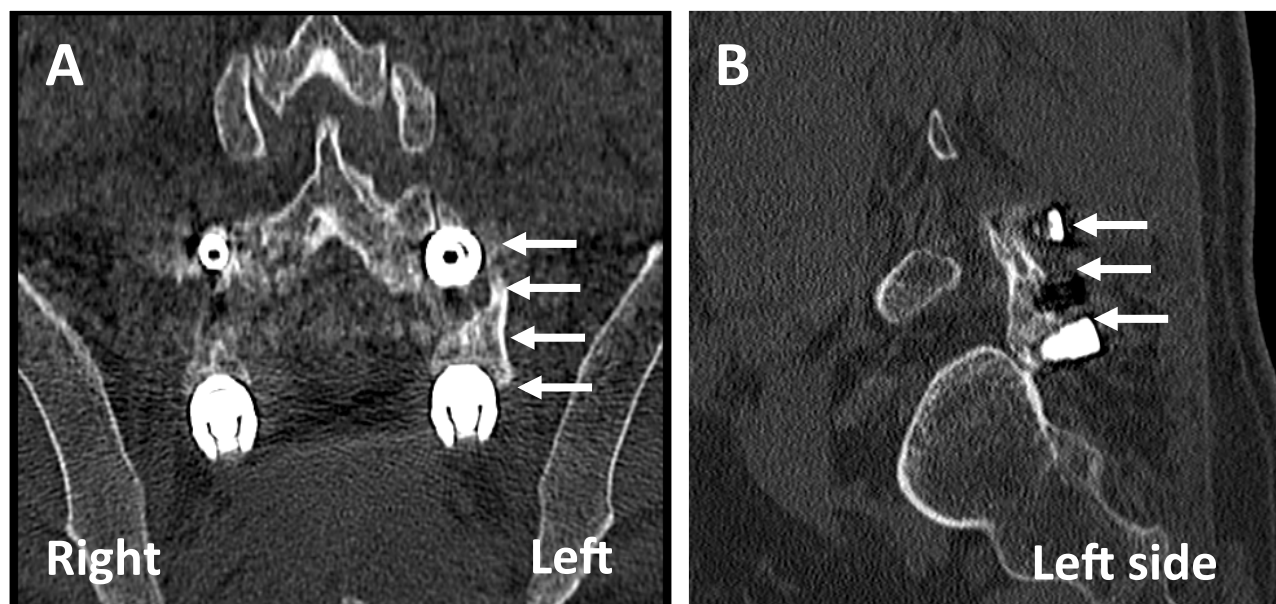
Representative CT images of patient who underwent posterolateral fusion showing instrumentation. Bone bridging along the instrumentation can be appreciated on the left side (Allograft + autologous BMC + PRP).
